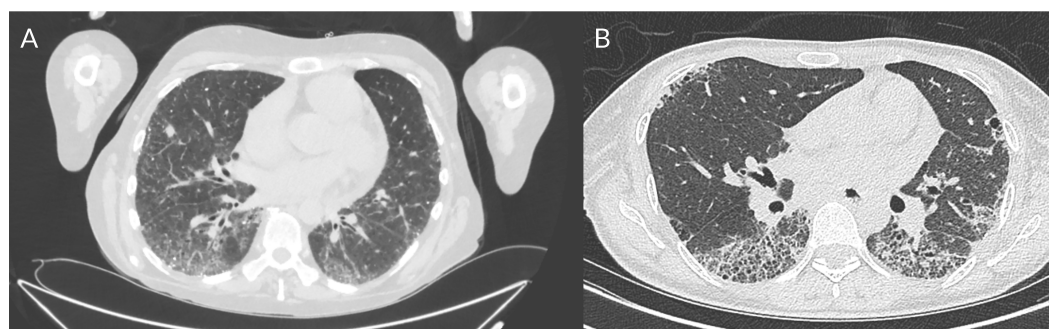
HRCT slices demonstrating. (A) Systemic sclerosis interstitial lung disease with moderate severity non-specific interstitial pneumonia pattern fibrosis characterised by relatively fine homogeneous reticulation and inflammatory change. (B) Systemic sclerosis interstitial lung disease with subpleural cyst formation, extensive reticulation, traction bronchiectasis typical of usual interstitial pneumonia pattern fibrosis. Permission has been obtained. HRCT, high resolution computerised tomography of the chest.
